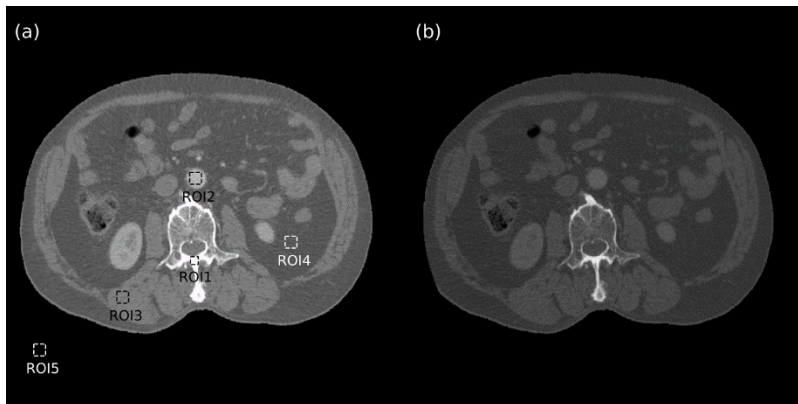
(a) The low energy: 100 kVp and (b) the high-energy: 140 kVp CT image of the pelvis patient. The material components of the ROIs are bone (ROI1), iodine (ROI2), muscle (ROI3), fat (ROI4), and air (ROI5). The displaying window is $[0.01,0.04]\text{mm}^{-1}$.
